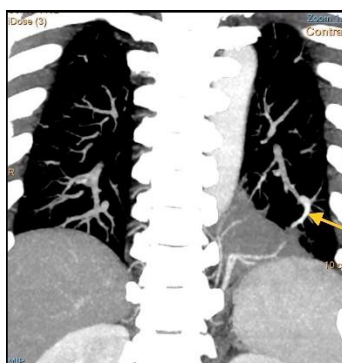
CT angiography thorax(delayed phase with mip) showing venous drainage into the pulmonary veins(yellow arrow)
